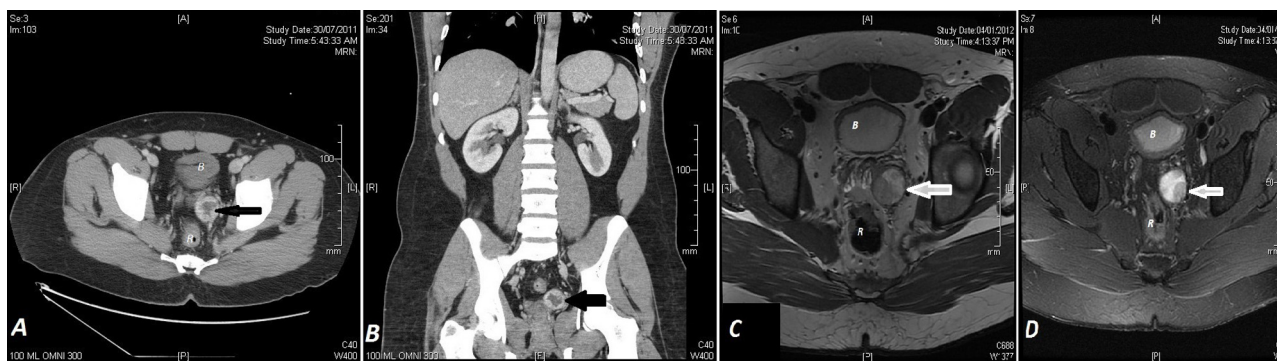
CT (A and B) and MRI (C and D) of abdomen and pelvis: showing a well-defined rounded left SV (arrow) enhancing necrotic mass measuring $2.7 \times 2.7 \times 2.9$ cm. (D) The lesion appears hyperintense on T2 and shows significant enhancement on the post contrast images mainly at its periphery. No regional lymphadenopathy or invasion of the adjacent structures. Bladder (B) and rectum (R).
